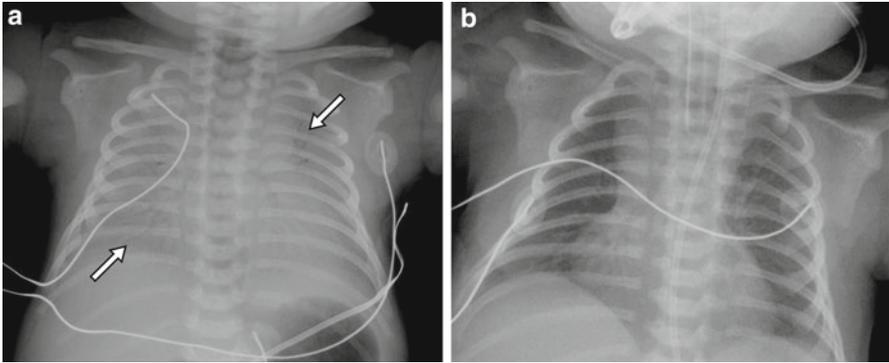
Respiratory distress syndrome. (a) Chest radiograph shows hypoventilated lungs with symmetrical, bilateral granular opacities and air bronchograms (*white arrows*). (b) Exam performed 24 h later after endotracheal intubation and surfactant treatment. Lung aeration has improved. Diffuse bilateral granular pattern persists
